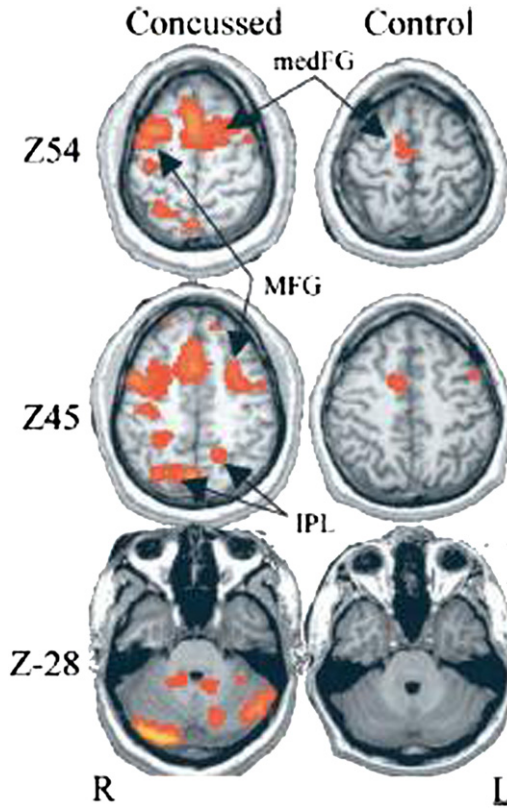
Representative individual z score differences between baseline and either a postconcussion session (concussed, left) or postseason baseline sessions (control, right). Colored areas show regions of activity that significantly increased from the baseline value of the bimanual sequencing task. Although both concussed and control subjects demonstrate some increases in region of activity, those of the concussed players are considerably larger. Activity is significantly increased in the medial frontal gyrus (medFG), middle frontal gyrus (MFG), inferior parietal lobe (IPL), and bilateral cerebellum. (From Jantzen Anderson B, Steinberg FL, et al. A prospective functional MR imaging study of mild traumatic brain injury in college football players. *AJNR Am J Neuroradiol* 2004;25(5):741.)
